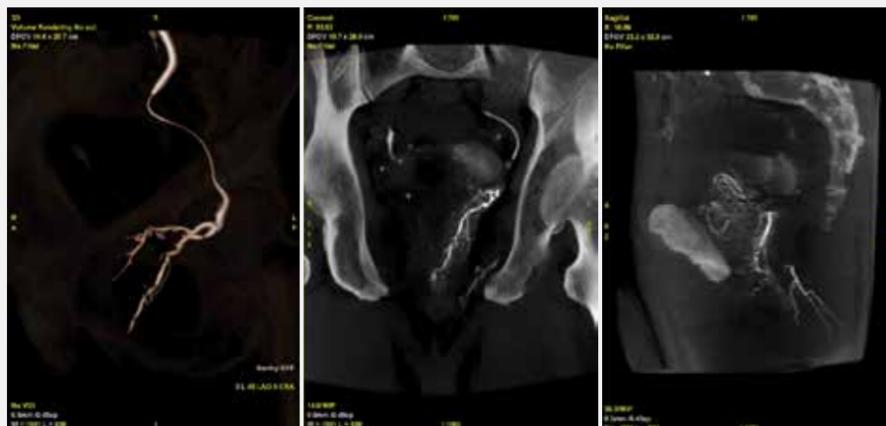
Left Prostatic Artery: Selective CBCT helped depict a rectal branch. To avoid risks of non-target embolization, a coil was deployed to protect the rectum. Left: Volume Rendering, Middle: Coronal view, Right: Sagittal view.
